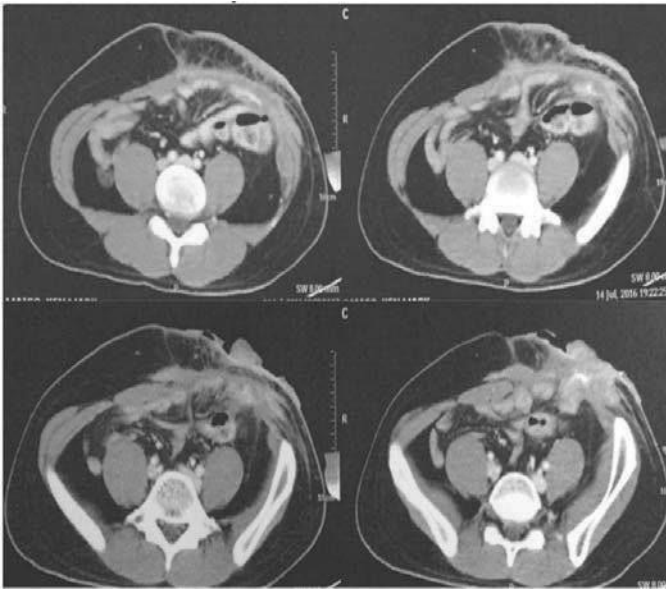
CT scan. Left lower abdominal wall mass (7.9cm x 6.8cm x 4.0cm) involving the lower rectus abdominis, transverse and oblique muscles, with extension to the right rectus muscle; (+) fistulous tract traversing the mass.
